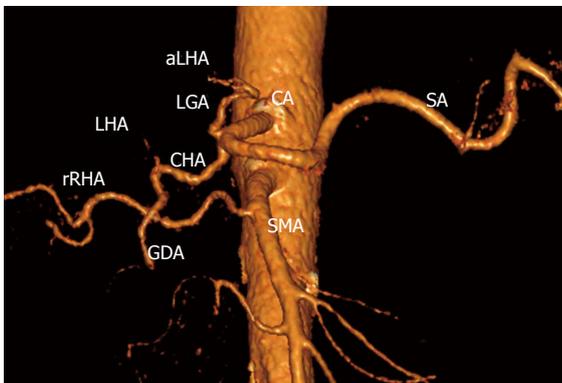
Three-dimensional computed tomography angiography before surgery. Variant arterial anatomy: replaced right hepatic artery (rRHA) originating from superior mesenteric artery (SMA), accessory left hepatic (aLHA) - from left gastric (LGA) (Michels, type VIIIb). CA: Celiac artery; LHA: Left hepatic artery; SA: Splenic artery; GDA: Gastroduodenal artery; CHA: Common hepatic.
